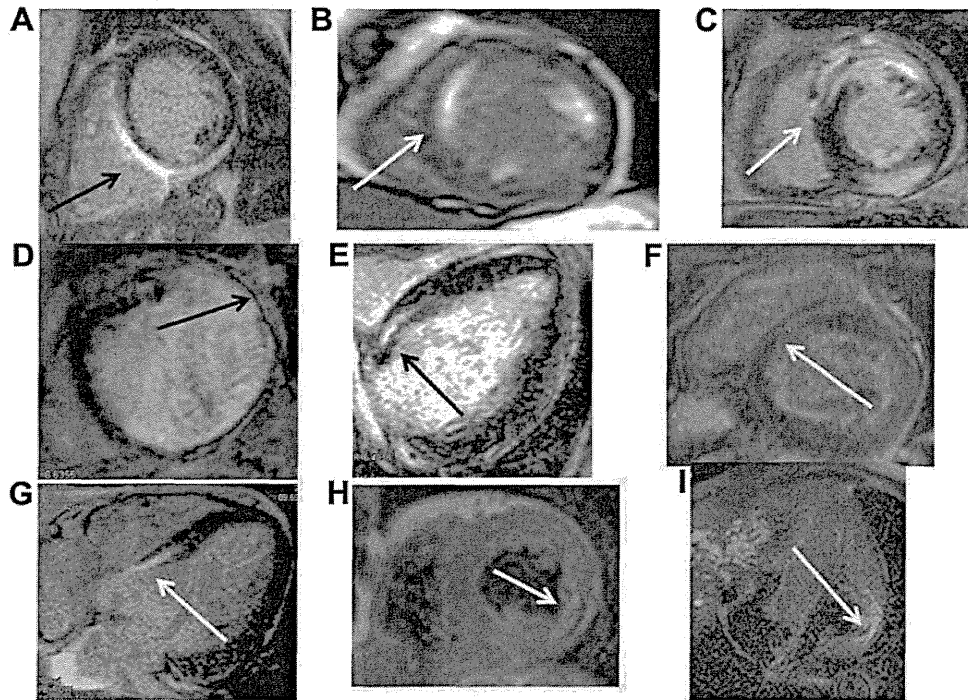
Findings of late gadolinium enhancement (LGE) and T2-weighted-imaging black blood (T2WI-BB) on cardiac magnetic resonance imaging. (A) LGE in epicardial wall in short-axis view in systemic cardiac sarcoidosis (sCS) case. (B) LGE in subendocardial wall in sCS case. (C) LGE in transmural wall in sCS case. (D) Epicardial LGE pattern in the lateral aneurysmal wall in isolated cardiac sarcoidosis (iCS) case (no. 2). (E) Mid to epicardial LGE pattern in 4-chamber view in iCS case (no. 4). (F) Epicardial to midwall LGE pattern in short-axis view in iCS case (no. 9). (G) Midwall LGE pattern in iCS case (no. 3). (H) Low intensity of the epicardial posterior scar on short-axis T2WI-BB image in sCS case. (I) High intensity of myocardial edema in the posterior aneurysmal wall on 4-chamber T2WI-BB image in iCS case (no. 10).
